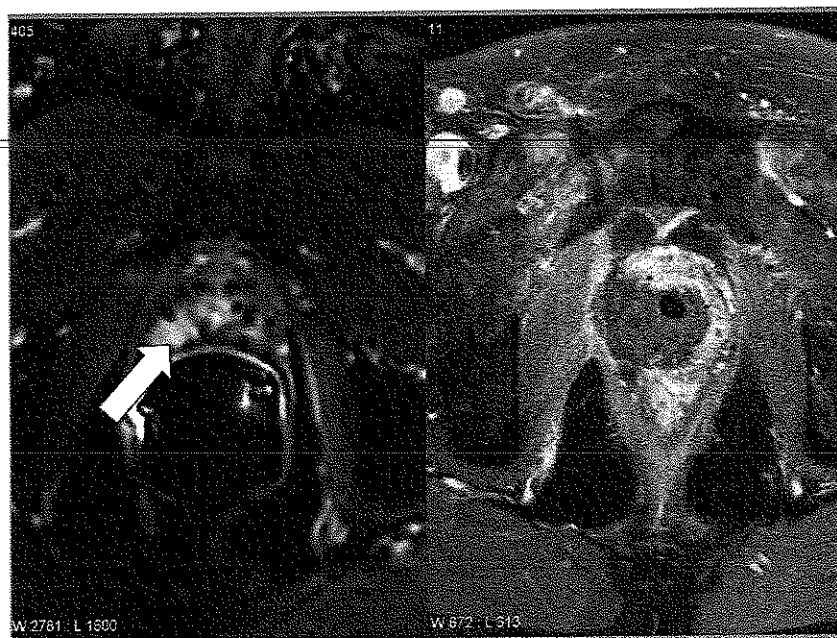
Focal HIFU after brachytherapy failure. The MRI on the left shows an enhancing tumour at the left peripheral zone extending to the right and crossing the midline. On the right, the post-operative MRI shows the destroyed area with no residual enhancement.
